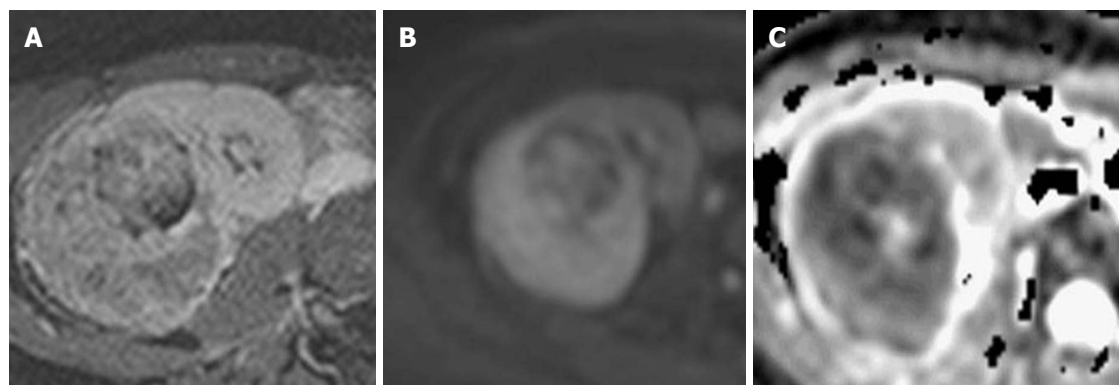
Renal cell carcinoma. (A) Heterogeneously enhancing mass on post contrast T1-weighted gradient recalled-echo image, demonstrating a high signal on (B) diffusion-weighted image and a low signal on (C) apparent diffusion coefficient, indicating impeded diffusion.
